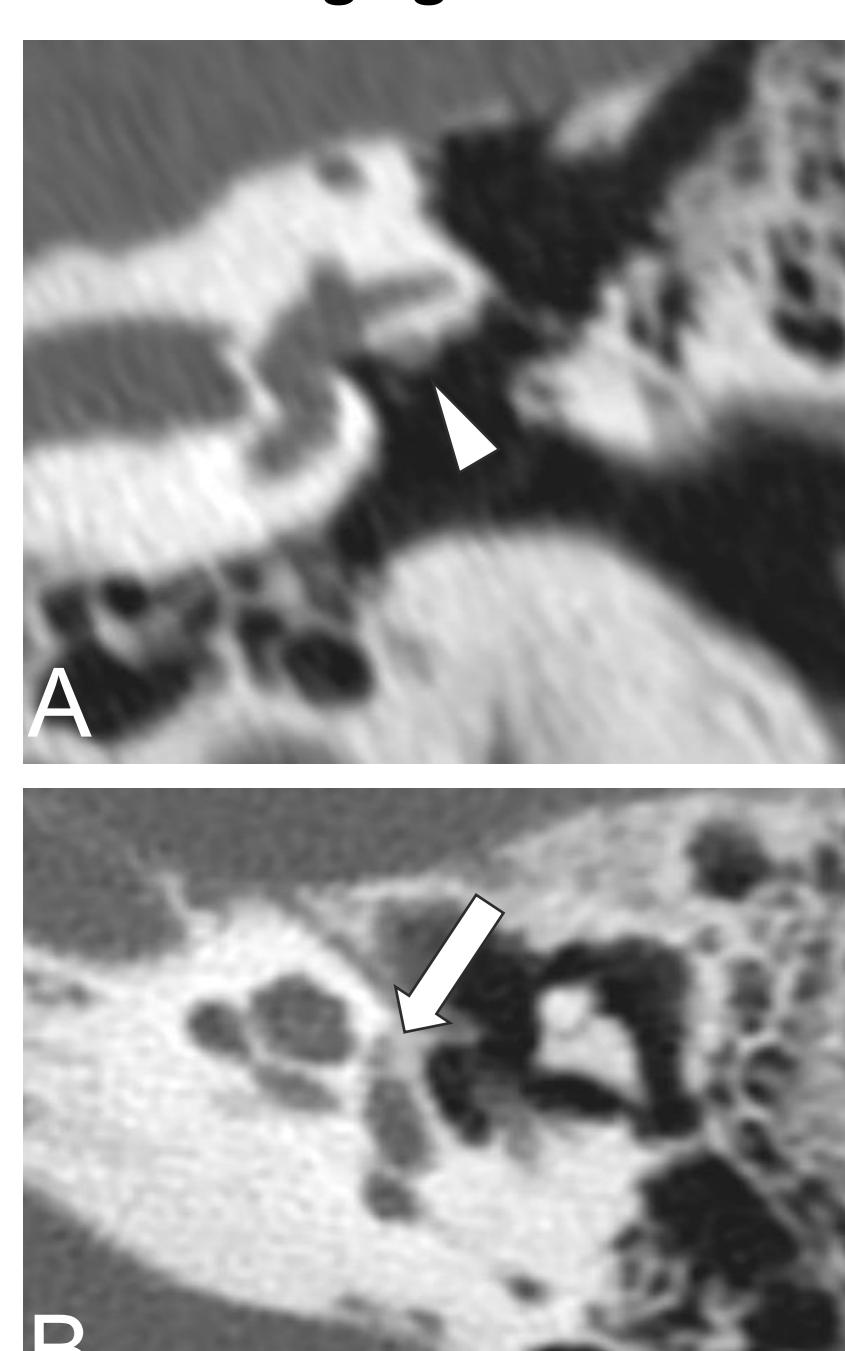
Coronal (A) and axial (B) CT images show dehiscence of the facial nerve canal with extension of the tympanic segment of the facial nerve below the bone margin (arrowhead), in this patient with fenestral otosclerosis (arrow).
